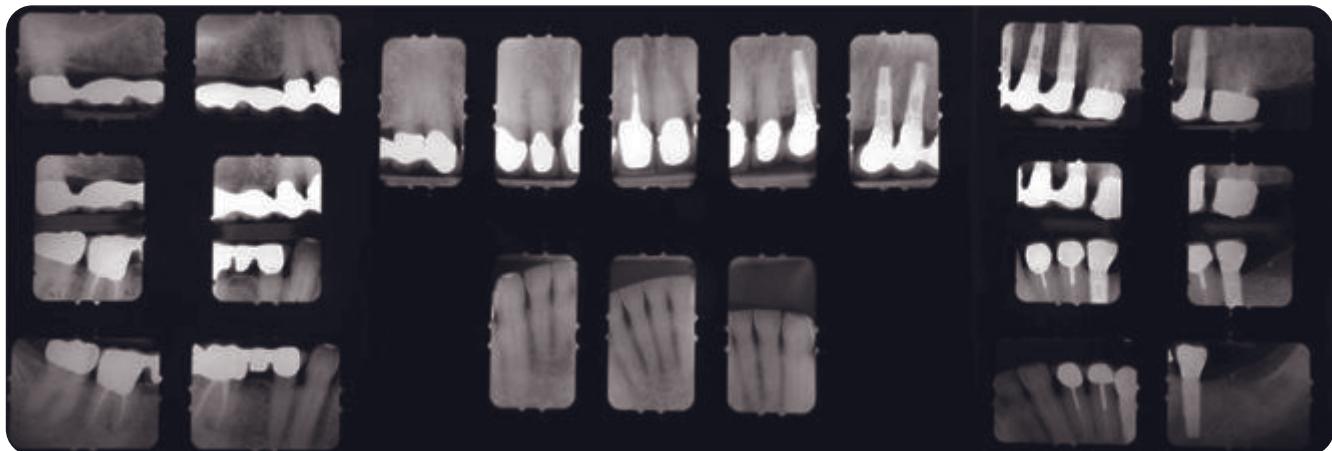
Posttreatment full mouth radiographs.
